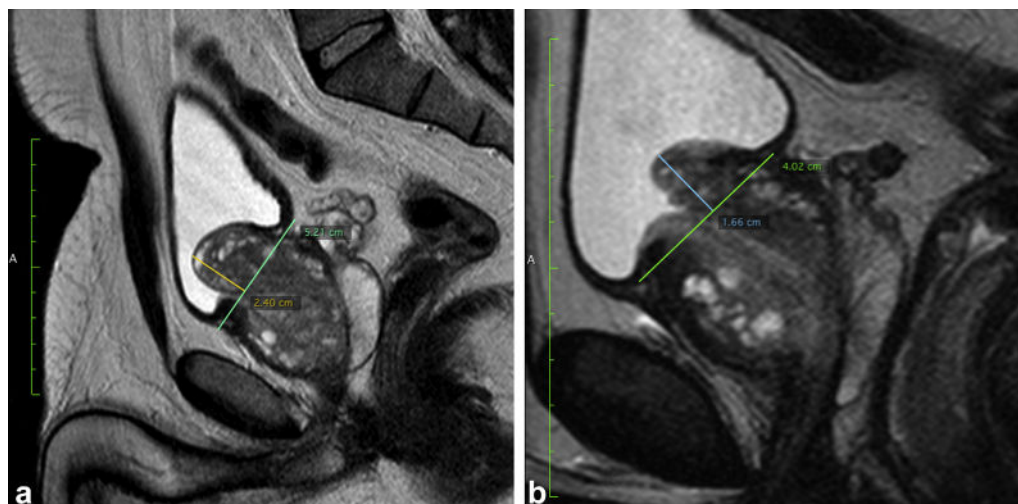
T2-weighted image in the sagittal plane. (a) Patient presenting with an intravesical prostatic protrusion (IPP) measured as 24 mm before embolization (grade III). (b) Reduction of IPP to 16 mm 12 months after PAE (grade II).
